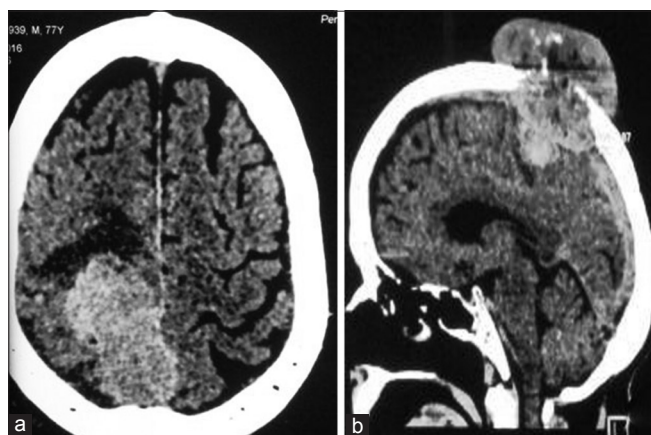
(a) Multidetector computed tomography high parietal region showing enhancing mass squeezing brain; (b) Multidetector computed tomography sagittal image showing intra- and extra-cranial mass extension
